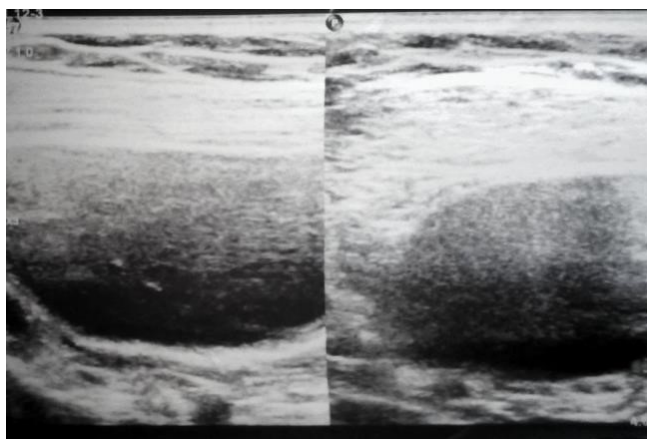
USG findings. A well-defined oval heterogeneously hypoechoic lesion measuring 25 × 23 mm in the right anterior chest wall region at 11 to 1 o'clock position. The lesion showed significant vascularity on color Doppler.
